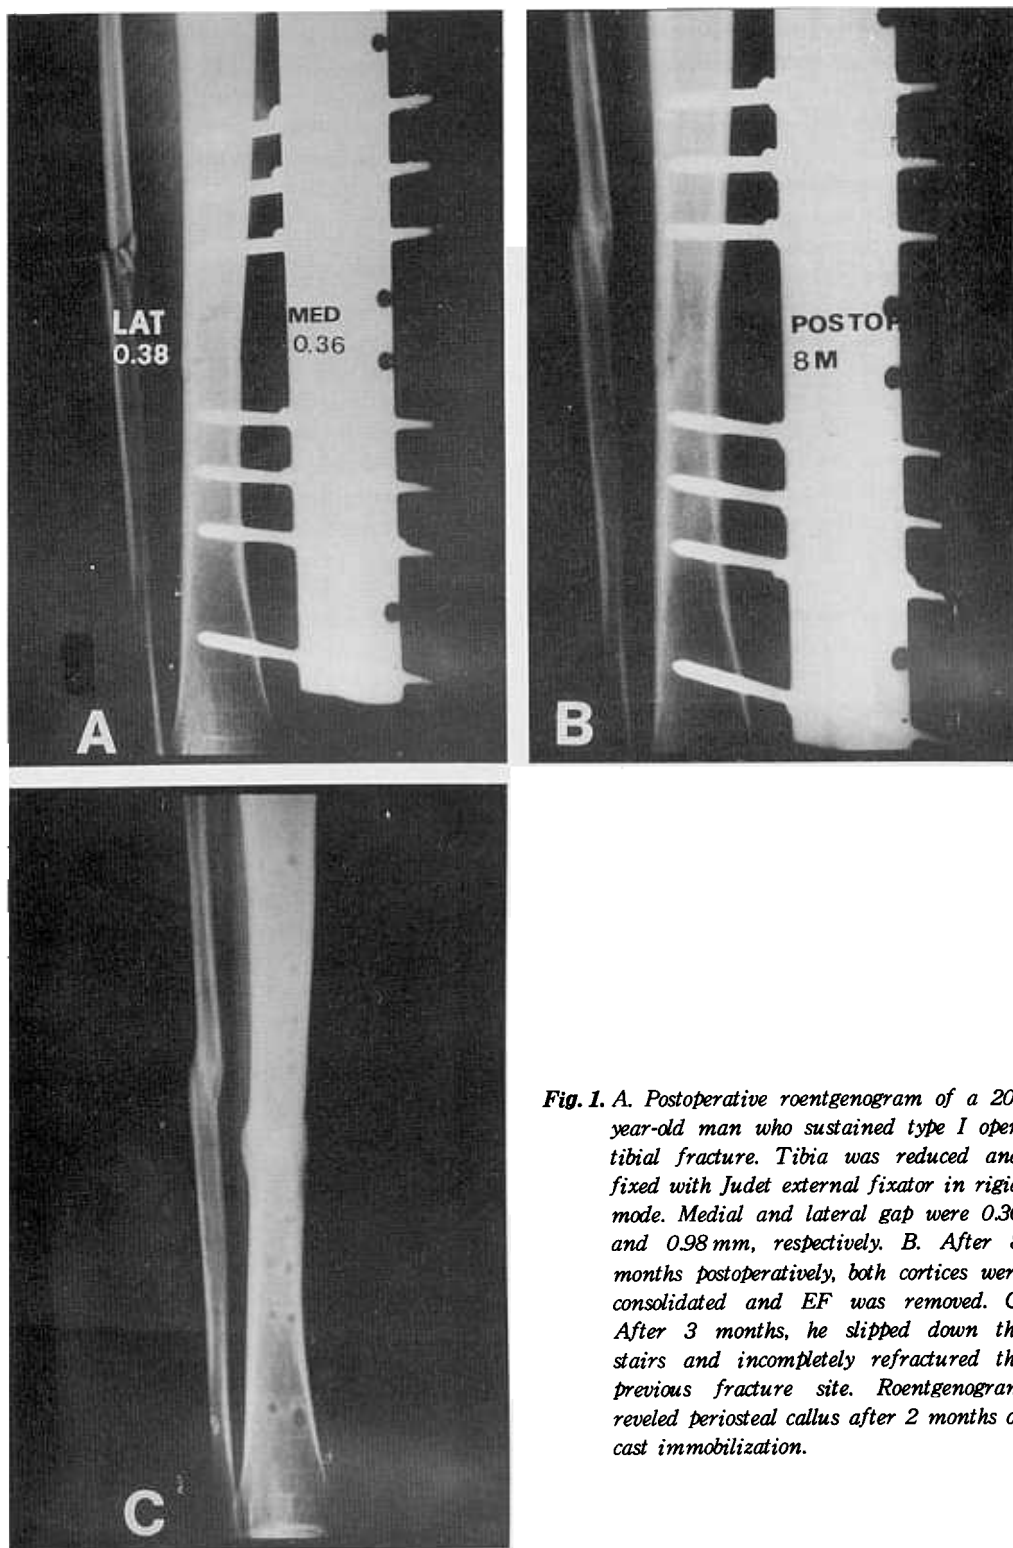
A. Postoperative roentgenogram of a 20-year-old man who sustained type I open tibial fracture. Tibia was reduced and fixed with Judet external fixator in rigid mode. Medial and lateral gap were 0.36 and 0.98 mm, respectively. B. After 8 months postoperatively, both cortices were consolidated and EF was removed. C. After 3 months, he slipped down the stairs and incompletely refractured the previous fracture site. Roentgenogram revealed periosteal callus after 2 months of cast immobilization.
